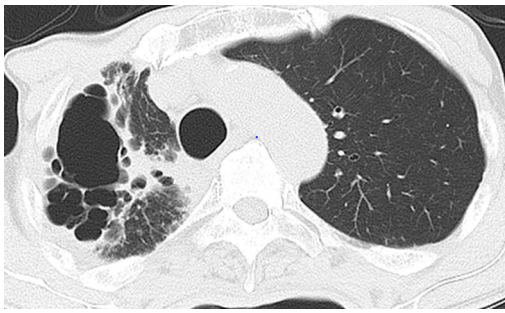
Typical computed tomography findings of a progressive destroyed lung.
